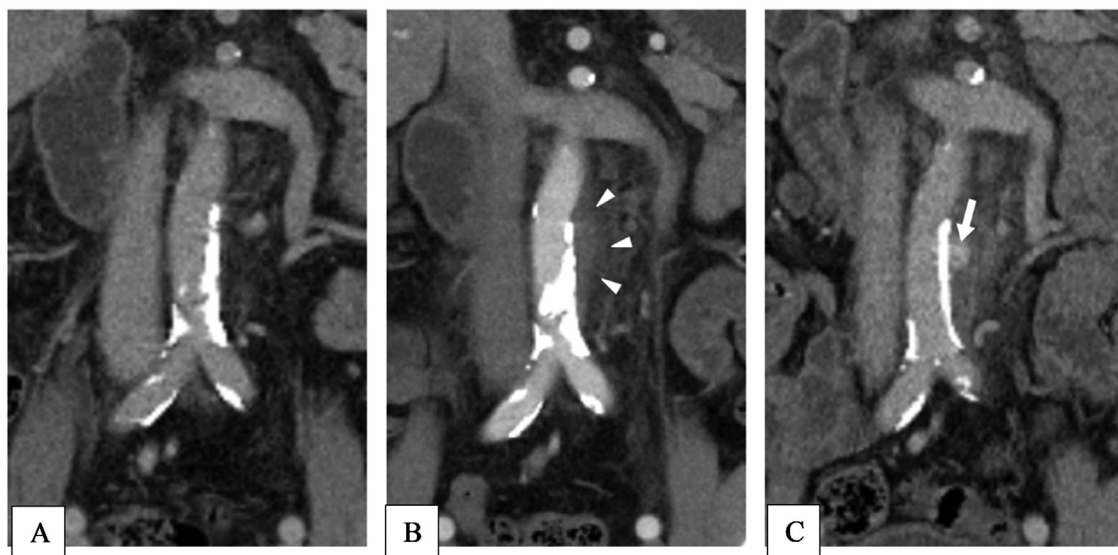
(A) The abdominal CT scan reveals the atherosclerotic change of the abdominal aorta and the common iliac artery. (B) (without contrast) and (C) (with contrast) show extravasation and rupture of the infected abdominal aneurysm at the third admission.
